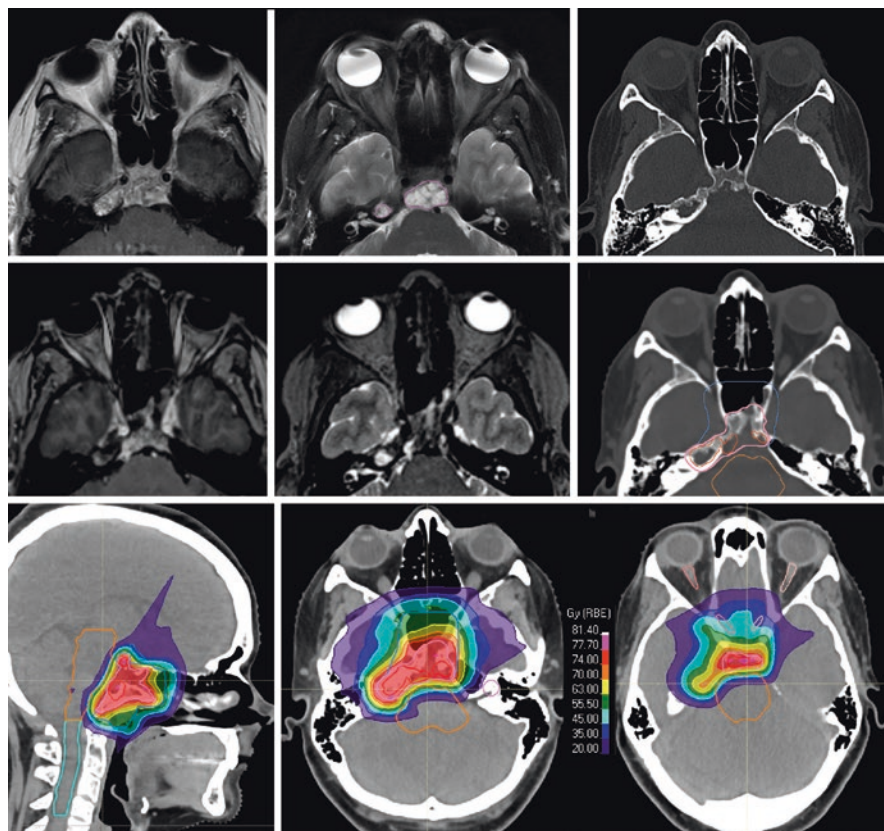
This patient presented with diplopia and a left cranial nerve VI palsy. The top row shows the preoperative imaging, with a T1 heterogeneously enhancing, T2 hyperintense tumor (note the second focus of tumor in the right petrous apex immediately adjacent to the right cochlea) and CT showing lytic process involving the majority of the clivus and a portion of the petrous apex of the right temporal bone. A transnasal transsphenoidal resection was performed with tumor debulking, pathology showing chordoma. The second row shows the postoperative imaging, with expected postoperative enhancement in the central skull base, and T2 MRI showing the residual focus of tumor in the right petrous apex and small blebs on the lateral margin of the central tumor bed resection. The radiation planning CT on the second row far right shows the T2 tumor in red, the target to receive 55.5 Gy in blue and the target to receive 74 Gy in pink, which includes all of the abnormal clivus. The proton dose colorwash shows the entire clivus is included in the 74 Gy volume, including good coverage of the posterior clinoids, in close proximity to the optic chiasm. The sphenoid sinus is covered in the 55.5 Gy volume. Due to the disease in the right petrous apex, it was not possible to spare the right cochlea, but the left cochlea received a mean dose of 6 Gy
